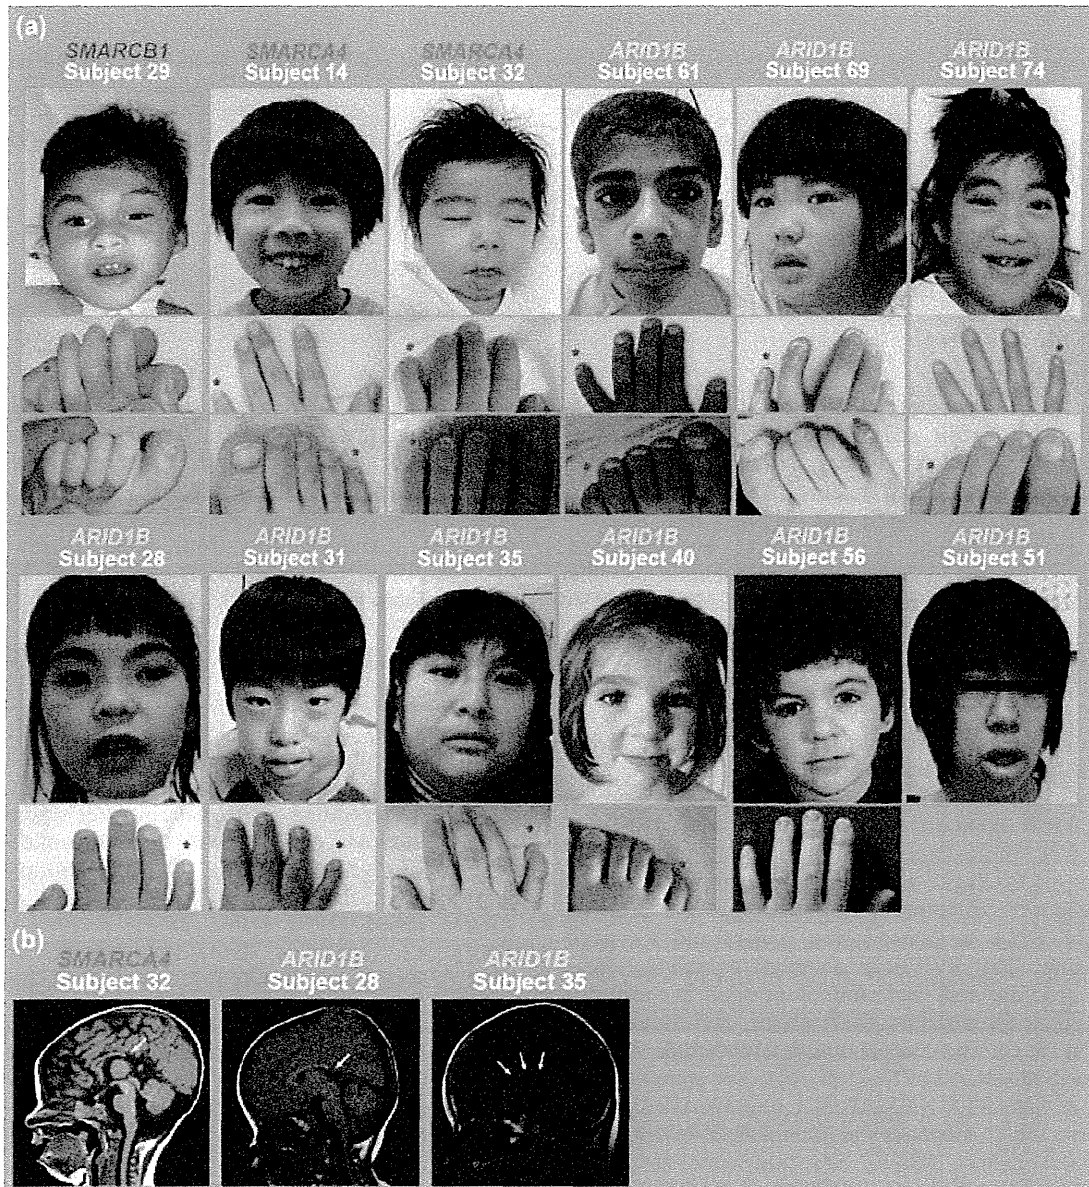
Photographs and brain magnetic resonance imaging findings in patients with Coffin–Siris syndrome. (a) Faces (top) and nails of the fingers (middle) or/and toes (bottom) of patients, with the mutated gene indicated. Red asterisks indicate the fifth finger/toe. (b) T1-weighted midline sagittal magnetic resonance images. The individuals showed agenesis of the corpus callosum (arrows).
